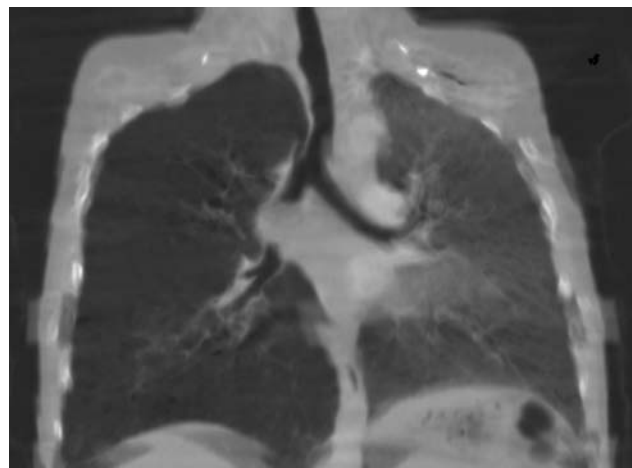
Coronal reformat CT shows the right main bronchus occlusion by a hypodens lesion (arrow)
